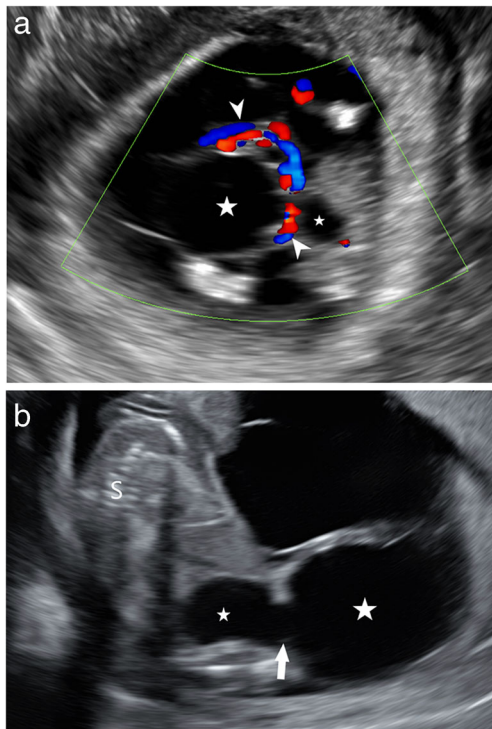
Prenatal ultrasound at 12 weeks' and 14 weeks' gestation. a A transverse image with Doppler from a fetal ultrasound at 12 weeks' gestation. The larger cyst (*large star*) represents an umbilical cord cyst (allantoic cyst) and the small cyst (*small star*) represents the fetal bladder. These are joined by a patent urachus forming a vesico-allantoic cyst. The umbilical vessels (*arrowheads*) are draped around the umbilical cord cyst. b A longitudinal image with Doppler from a fetal ultrasound at 14 weeks' gestation. The open channel (*arrow*) connecting the fetal bladder (*small star*) and the allantoic cyst (*large star*) is seen to better advantage and represents a patent urachus. *S* fetal spine
